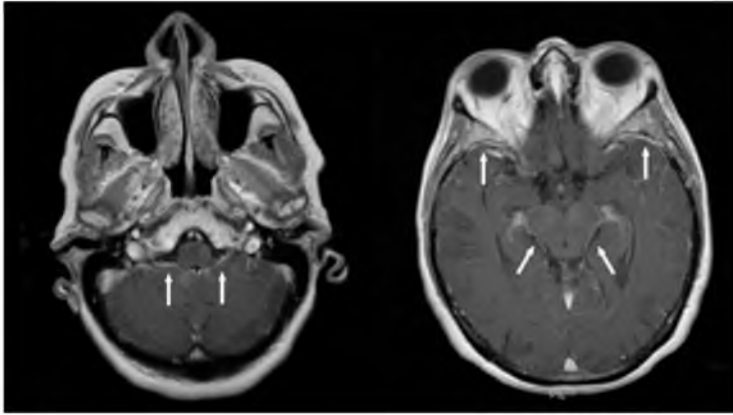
Axial T1 weighted MRI images of the brain after intravenous administration of 15 ml Gd-DOTA in a 62 year old patient 5 years after detection and treatment of a pT2N3a ILC, who presented with nausea, vomiting and confusion. Note the diffuse leptomeningeal enhancement (arrows), which was later shown to be meningeal carcinomatosis (diffuse ILC metastasis) by lumbar puncture.
